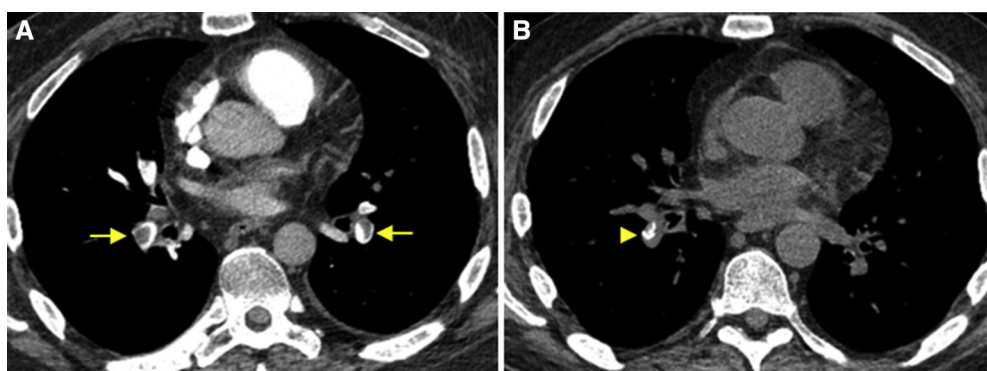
A 47-year-old man with recent diagnosis of acute lymphocytic leukaemia. (A) Initial computed tomography pulmonary angiography demonstrates acute pulmonary emboli (arrows). (B) Follow-up nonenhanced chest computed tomography performed 9 months later demonstrates eccentric intraluminal calcification in the right interlobar pulmonary artery (arrowhead), consistent with chronic pulmonary embolus.
